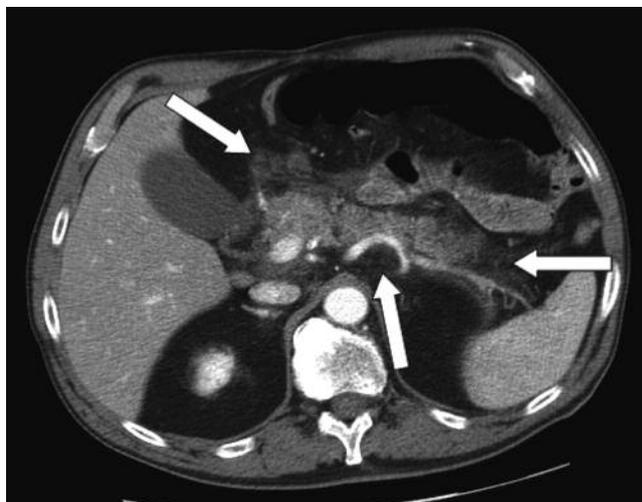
Contrast-enhanced CT image showing the peripancreatic fat stranding (arrows), without necrosis of the pancreas (Balthazar grade C, severity index 2).
